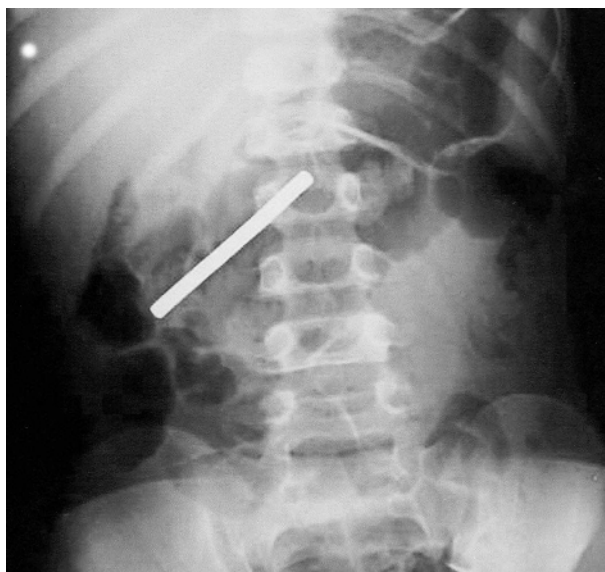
Radiographs of the foreign bodies swallowed by the case patient.
